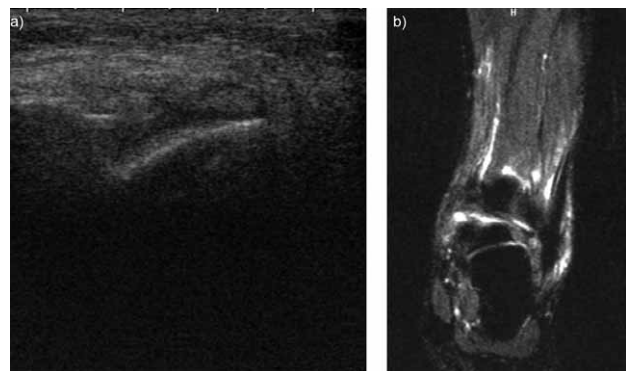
a) (Ultrasound) Effusion (Lesion G1) in left talocrural joint [Case 30.Di.Fr]; 7.b) (Magnetic resonance) Effusion (Lesion G1) in the left talocrural joint.
